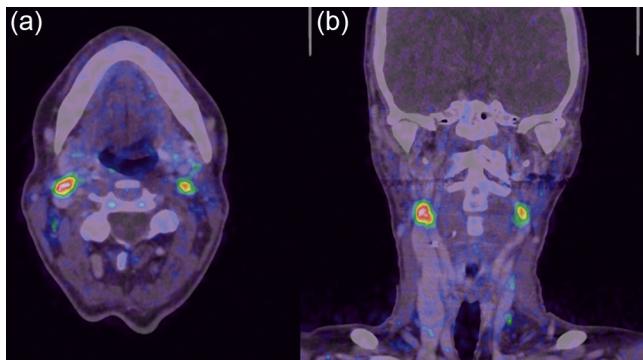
Patient (no. 6) with paranasal sinus carcinoma – axial (a) and coronal (b) view. According to the staging ultrasound investigation only benign cervical lymph nodes bilaterally. In the right upper jugular region increased FLT accumulation due to tumour infiltration, on the left side reactively changed node.
